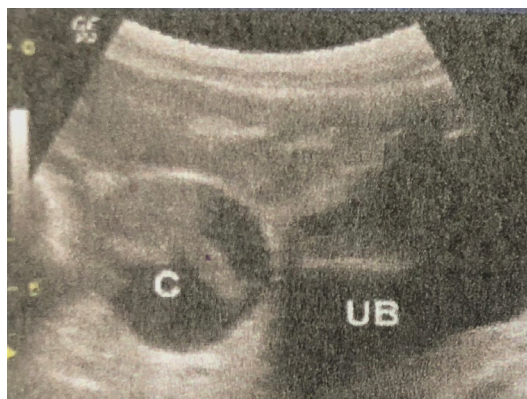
Ultrasound showing the cyst (C) abutting the urinary bladder (UB).
